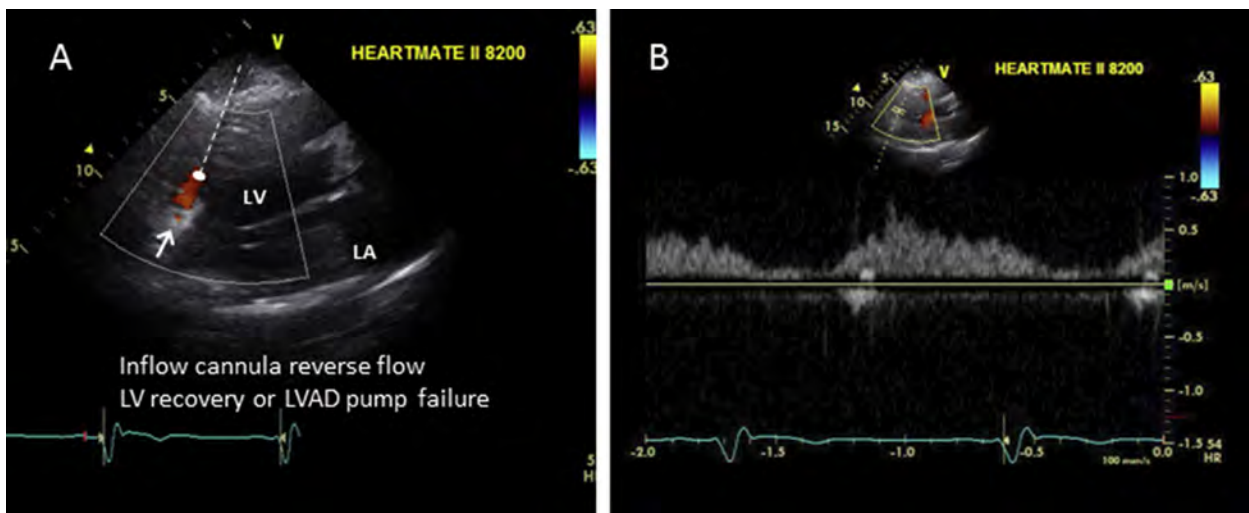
TTE, in the modified parasternal long-axis view, shows HM-II inflow-cannula diastolic flow reversal in a normally functioning LVAD at a relatively low pump speed (8200 rpm) in a patient with significant LV recovery (see moving image). (A) Color-flow Doppler image. The inflow cannula is denoted by an arrow. See also Video 34. (B) Pulsed spectral Doppler image of the inflow cannula shows reduced systolic forward flow but pandiastolic regurgitant flow (aorta to left ventricle) due to improved diastolic recoil. *Note:* A similar Doppler pattern is seen with LVAD pump arrest, although such arrest is associated with symptoms and echocardiographic signs of HF.
